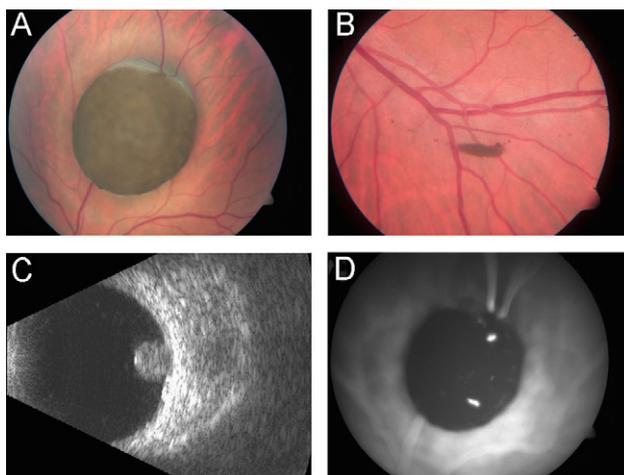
A, Funduscopy of a heavily pigmented lesion obscuring the retinal vasculature. B, Dispersion of pigmented cells on retinal surface along the inferotemporal arcade. C, Ultrasonography shows a round-shaped lesion of 5.6 mm thickness. D, Fluorescein angiography shows fluorescein leakage from engorged vessels at the tumour apex.
